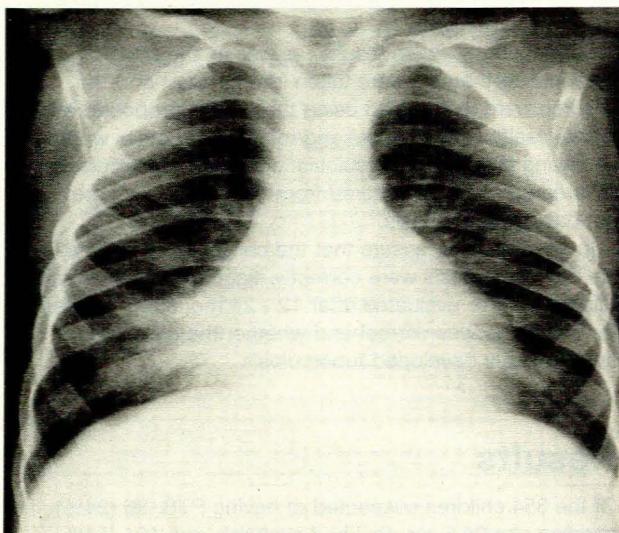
Chest radiograph of a child after an acute asthma attack which resulted in mucus plugging of the right middle lobe bronchus and lobar collapse.
